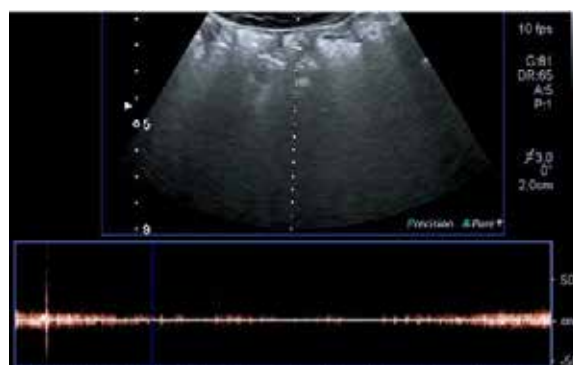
Doppler signal of a healthy subject intestinal peristalsis
